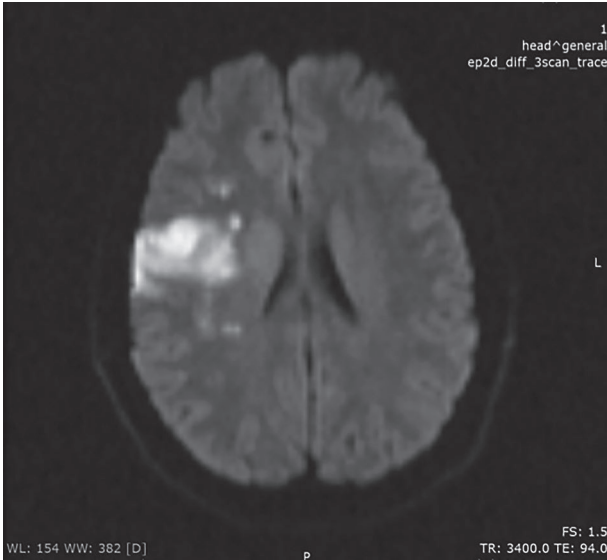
Brain magnetic resonance imaging showing right middle cerebral artery infarct.
